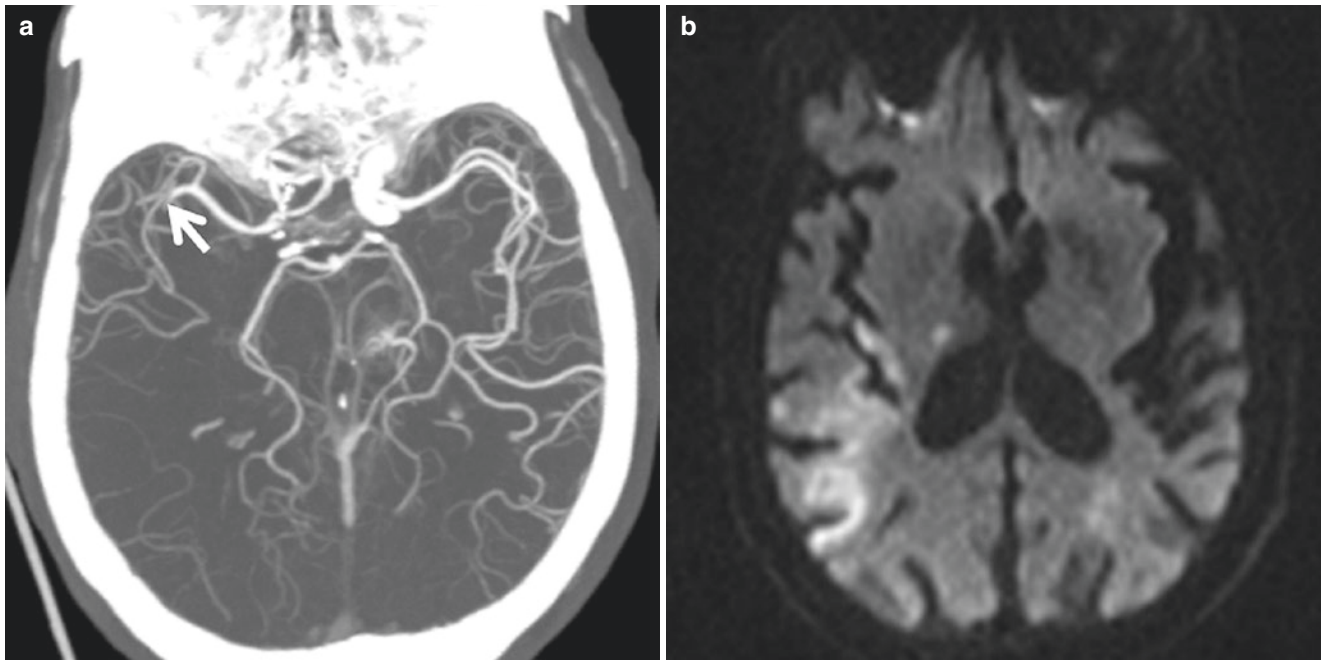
MCA inferior division infarction. (a), Axial CTA MIP demonstrates occlusion of right MCA inferior/posterior division at the origin. (b), MRI DWI shows acute infarction in the posterior insula, inferior parietal, and posterior temporal region
